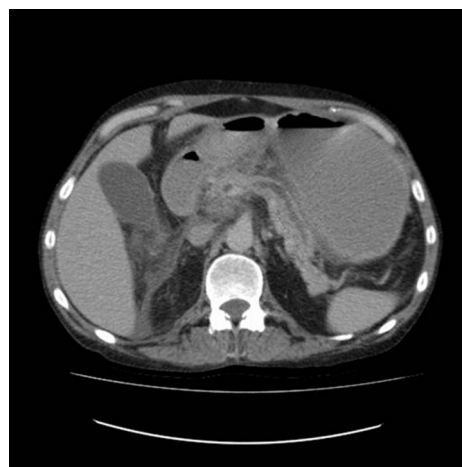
Computed tomography of pancreas showing severe pancreatitis.
